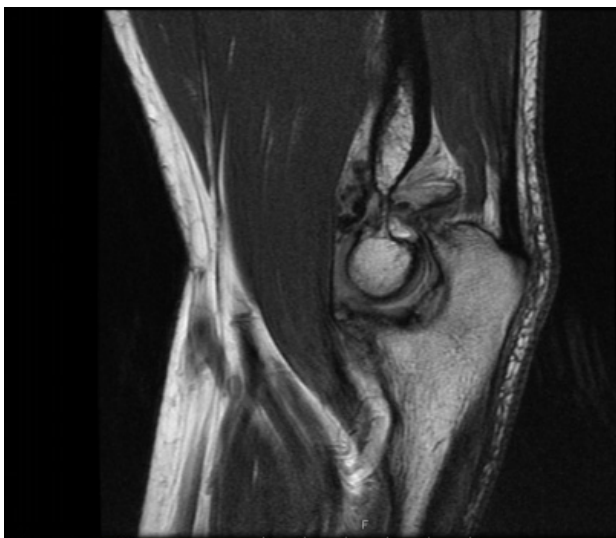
MRI Sagittal T1 sequence showing low signal multiple loose bodies anteriorly in the joint, tip of coronoid process and ulna trochlear arthropathy
